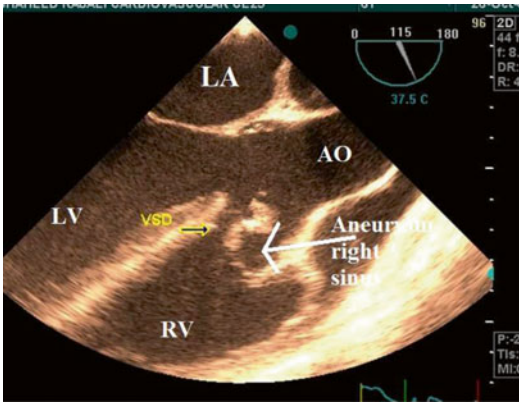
Transesophageal echocardiography in long-axis view revealed a “windsock” dilatation of the right sinus of Valsalva which is ruptured to the RVOT (white arrow) and associated VSD (yellow arrow). LA left atrium, LV left ventricle, AO aorta, RV right ventricle
